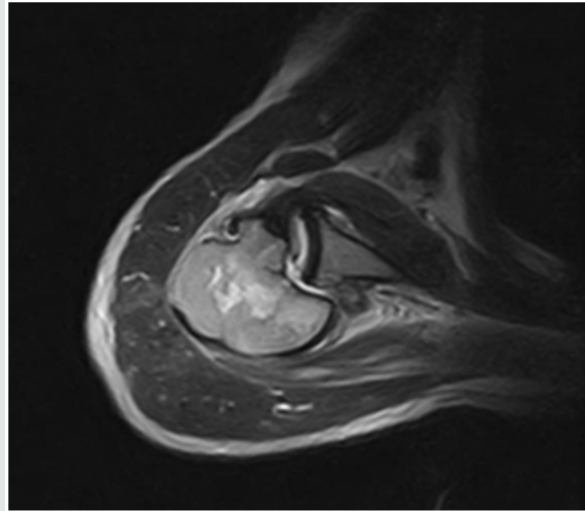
MRI Showing Reverse Hill-Sachs Lesion.
